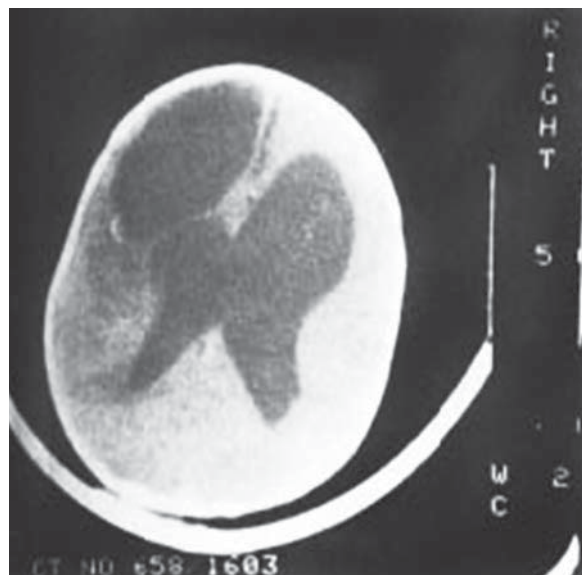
Computed tomography scan demonstrating porencephalic cysts in left frontal region.
